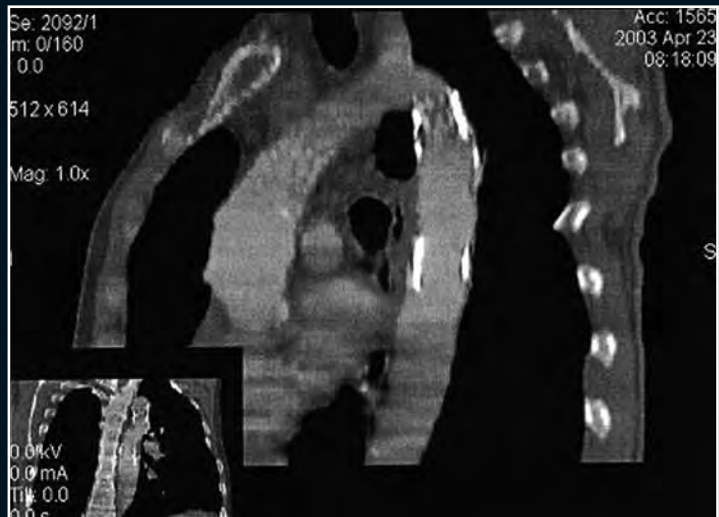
CT scan of Patient V. 10 years after procedure.
